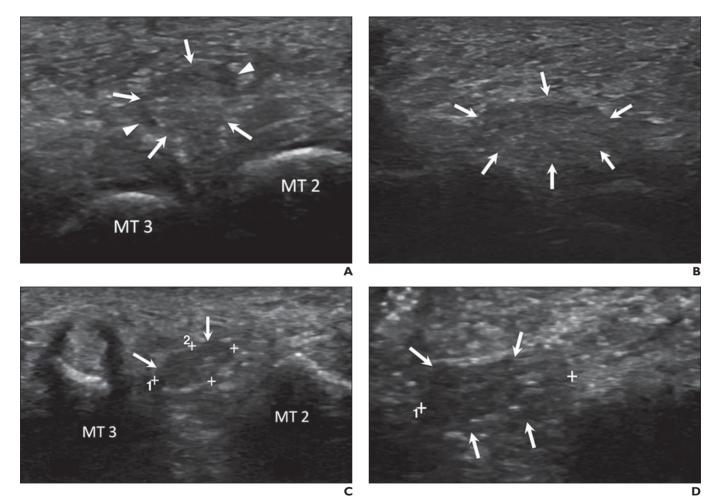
68-year-old woman with right foot metatarsalgia at second interspace who underwent high-intensity laser therapy (HILT) for treatment of Morton neuroma. A and B, Gray-scale short-axis (transverse) (A) and long-axis (B) ultrasound (US) images obtained before HILT during positive Mulder test show hypoechoic lesion (arrows) arising between second (MT 2) and third (MT 3) metatarsal heads surrounded by hypoechoic bursal fluid (arrowheads, A); these findings are consistent with Morton neuroma and associated bursitis. In real-time US examination, lesion was seen in continuity with digital plantar nerve.
